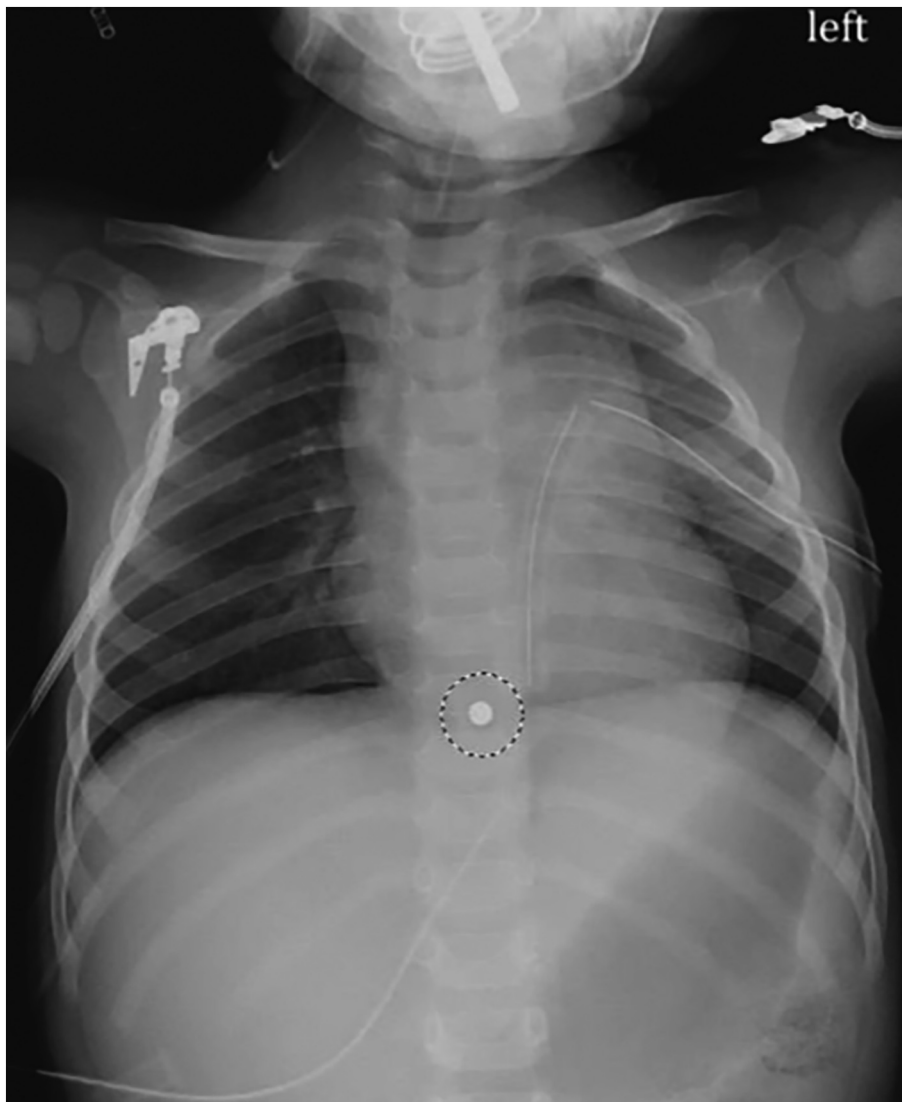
Chest radiograph of pellet that had injured the pulmonary artery then penetrated the pericardial sac, causing tamponade and near-arrest.
